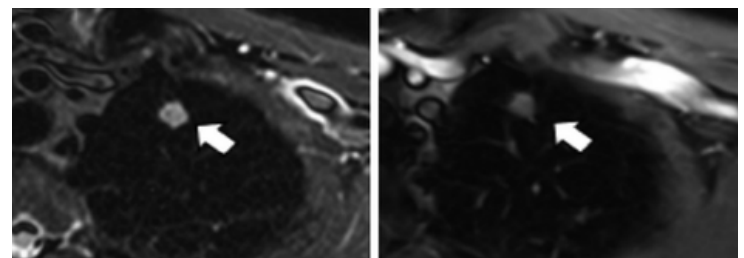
10 mm solid nodule in the left upper lobe in a 58-year-old man. The nodule (arrows) was clearly visible using all magnetic resonance imaging (MRI) sequences and classified as Lung-RADS 4X because of a spiculated margin.(A) MRI T2 short inversion time inversion recovery, and (B) MRI contrast-enhanced fat-saturated T1-weighted images.
